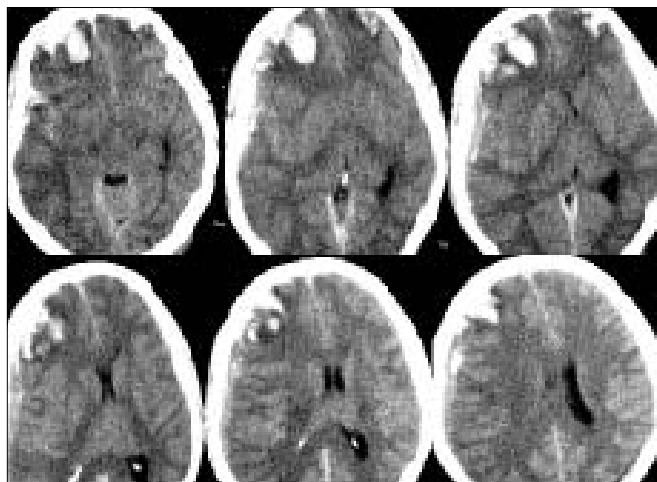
First CT scan of case 1 showing bifrontal ICH more on right side and an acute SDH in right fronto-temporo-parietal region
